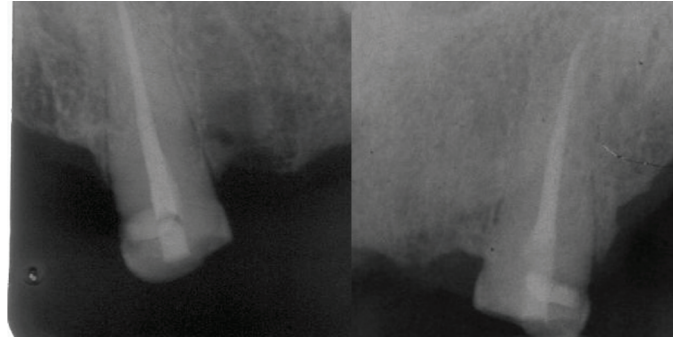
Periapicals of #13 and #23 after root canal therapy, and having been prepared as overdenture abutments.
